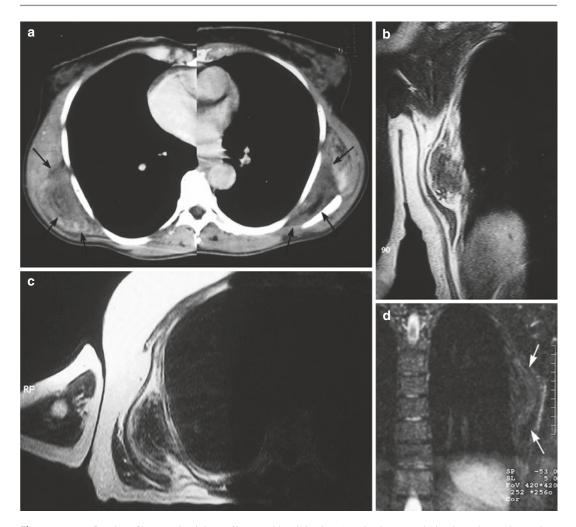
(a–d) Elastofibroma dorsi in a 60-year-old woman (a), in a 67-year-old woman (b, c), and in a 56-year-old woman (d). A CT scan after iodinated contrast injection. (b) Coronal spin-echo T1-weighted MR image. (c) Axial turbo spin-echo T2-weighted MR image. (d) Coronal STIR MR image. On the CT scan, there is an oval mass between the rhomboid major and latissimus dorsi muscles on both sides (*arrows*). The lesions show mixed attenuation and enhancement after iodinated contrast
